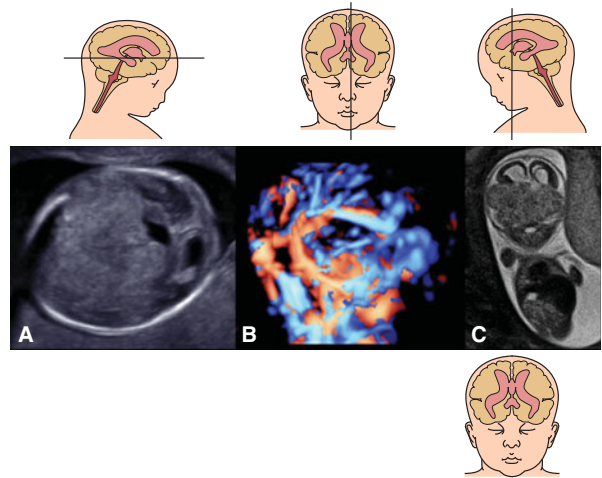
Brain tumor at 14 postmenstrual weeks of gestation. (A) 2D axial section. A large hyperechogenic mass occupies more than half of the cranial cavity. (B) Intratumoral vascularity demonstrated by 3D bidirectional power Doppler angiogram. (C) Fetal magnetic resonance imaging (MRI): coronal image. Bilaterally, the hemispheres are displaced above the tumor.
